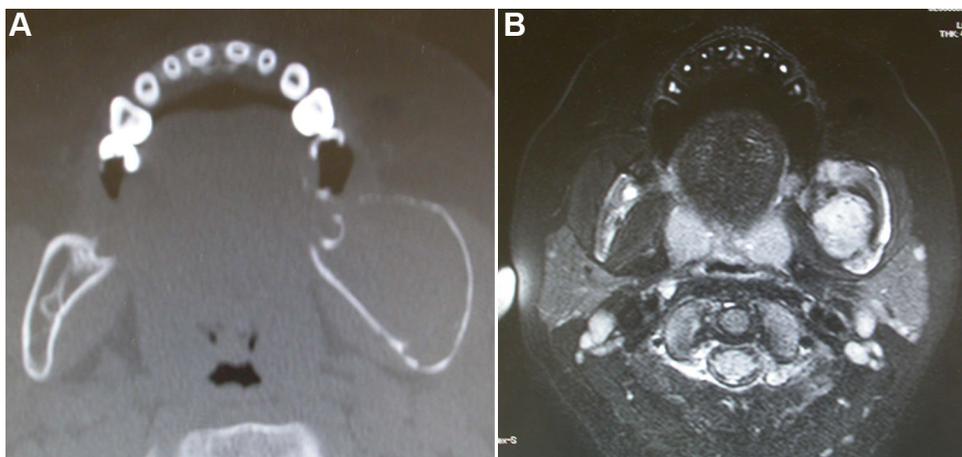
CT scan (A) and magnetic resonance imaging (B) showing a widespread mass lesion. The size of the mass was 35 mm × 25 mm × 17 mm.
